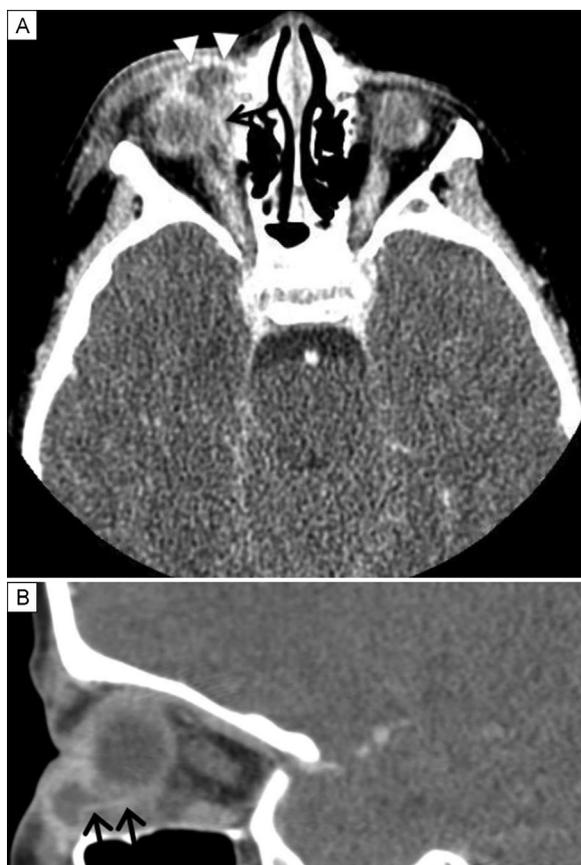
Preoperative computed tomography. A, axial contrast image of the abscess (white arrowheads) and foreign body (black arrow). B, Sagittal contrast image of the abscess anteriorly and the linear foreign body (black arrows).
